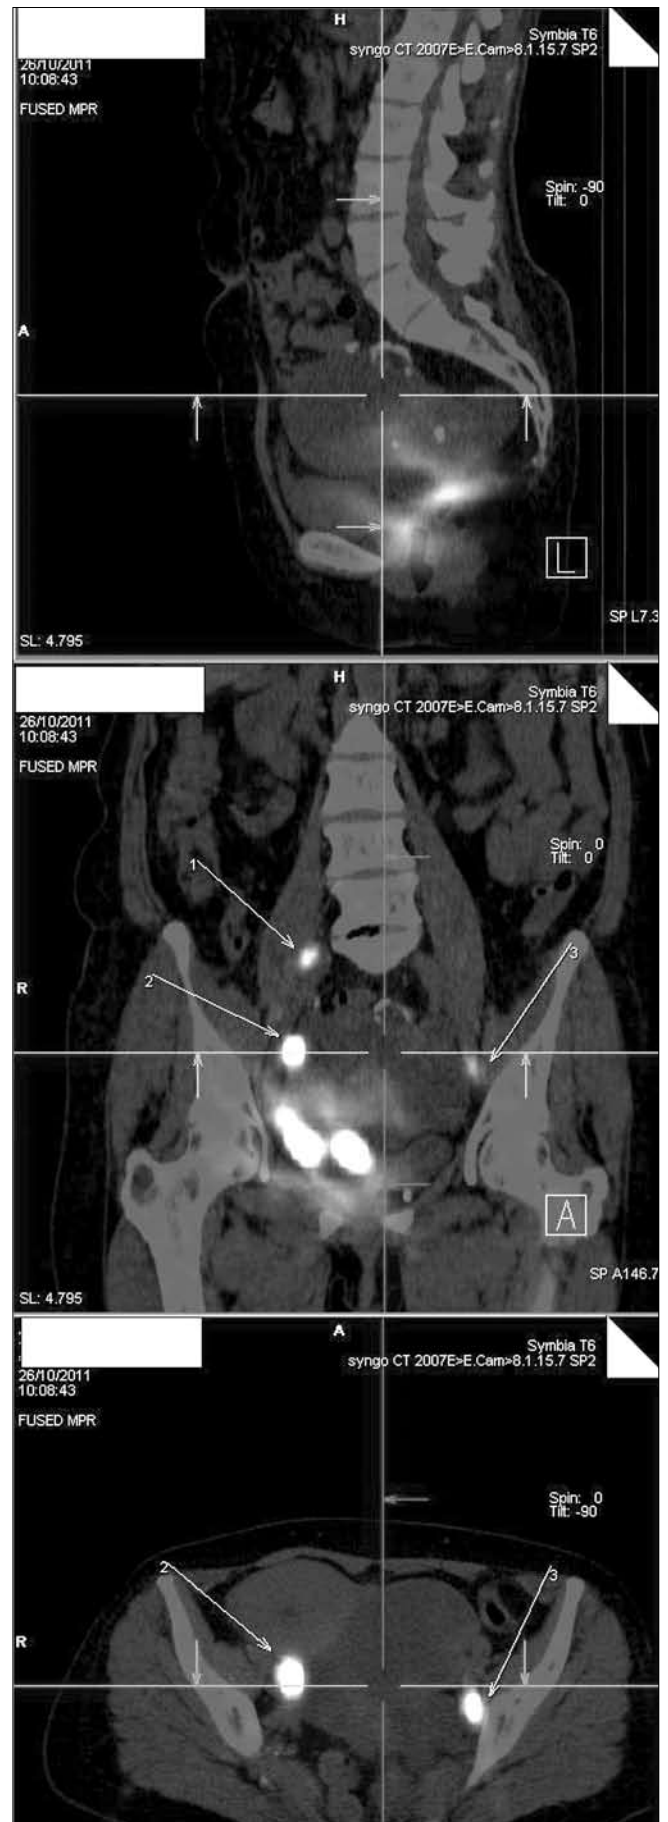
SPECT-CT scans of the detected sentinel lymph nodes in the first case.
